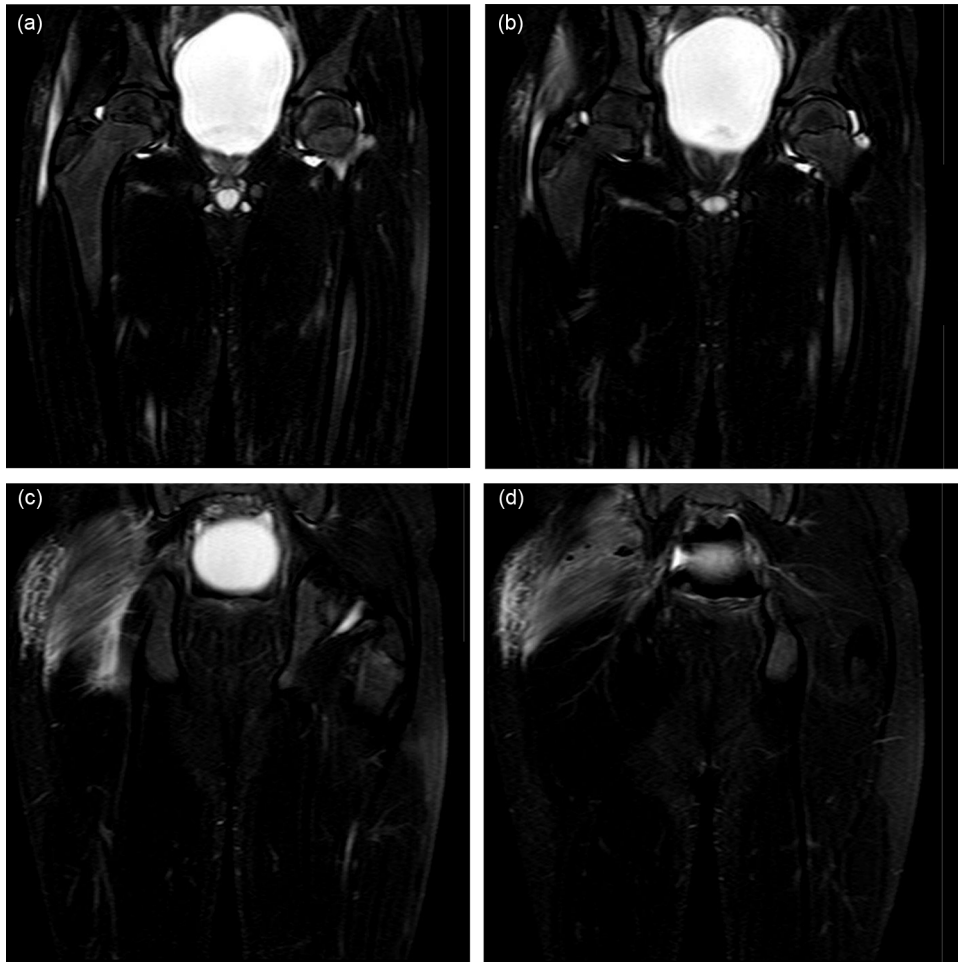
Coronal T2 fat saturated MRI sequences demonstrating small left hip effusion (a and b), and significant right sided soft tissue oedema affecting subcutaneous and muscle tissue from anterior to the trochanteric region posteriorly to the sacral margin (c and d). Multiple globular low signal foci in muscle (d) represent injection site granulomata, likely resulting from previous intramuscular injections.
